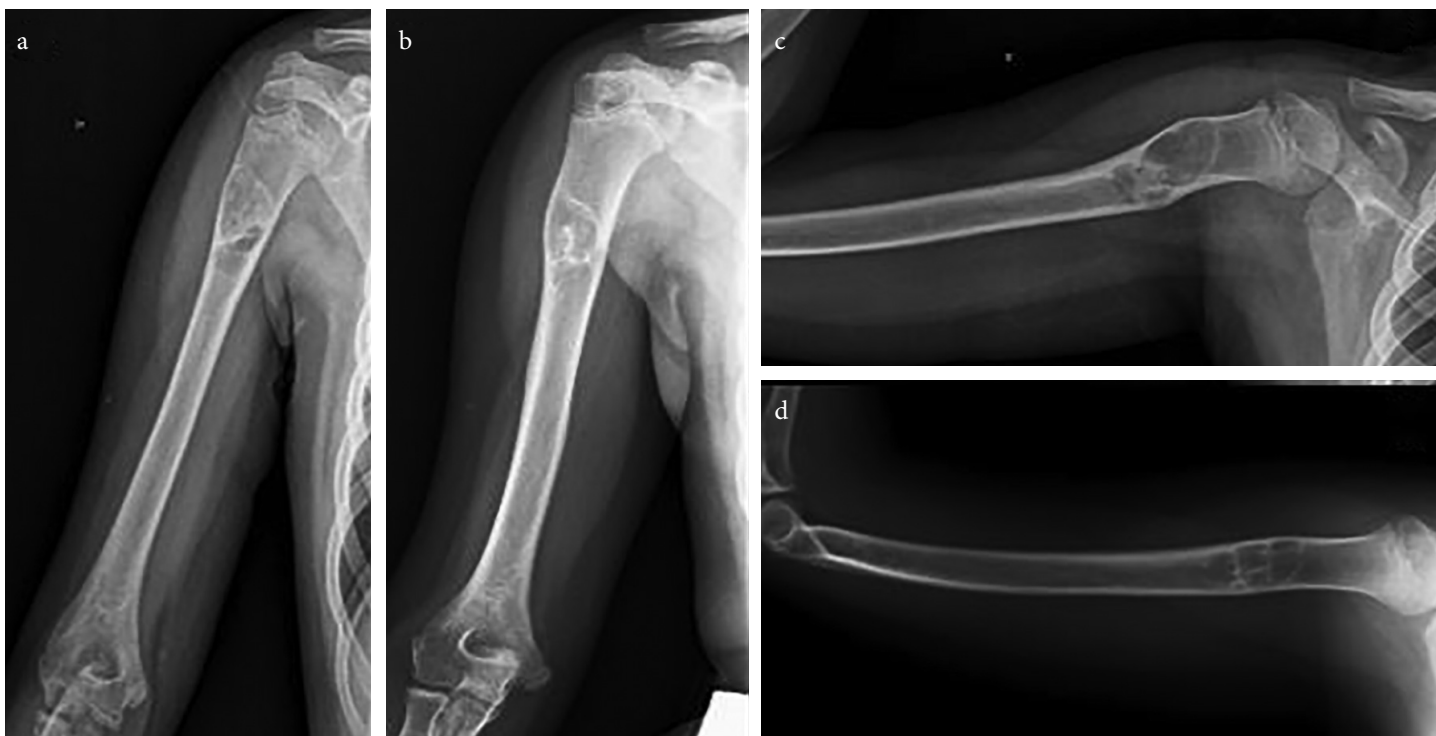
a-d. Proximal humeral cyst successfully treated with EDDBM+BMC injections; pre-operative (a, c) and post-operative (b, d) x-rays (failure)
